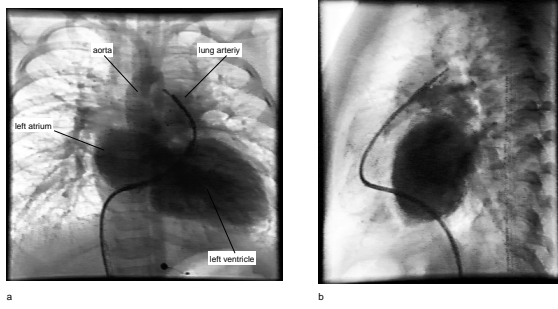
Angiograms acquired by the bi-plane x-ray system
